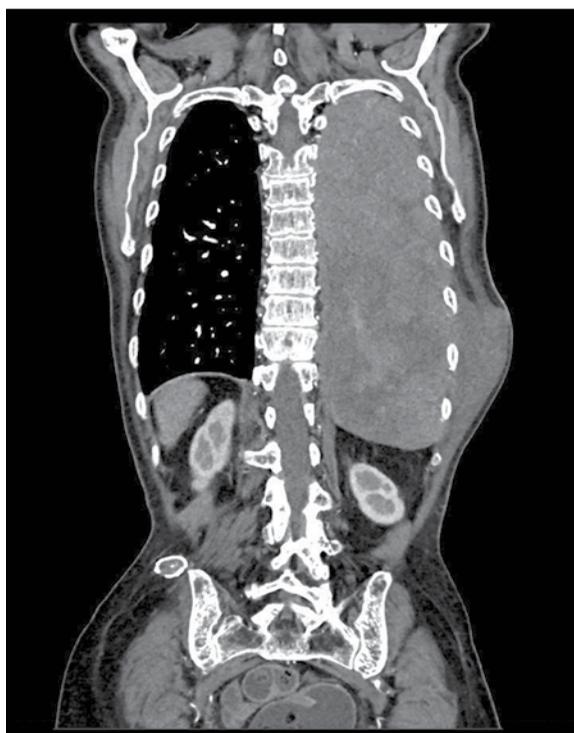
Chest CT, MPR reconstruction. Left chest wall invasion.
